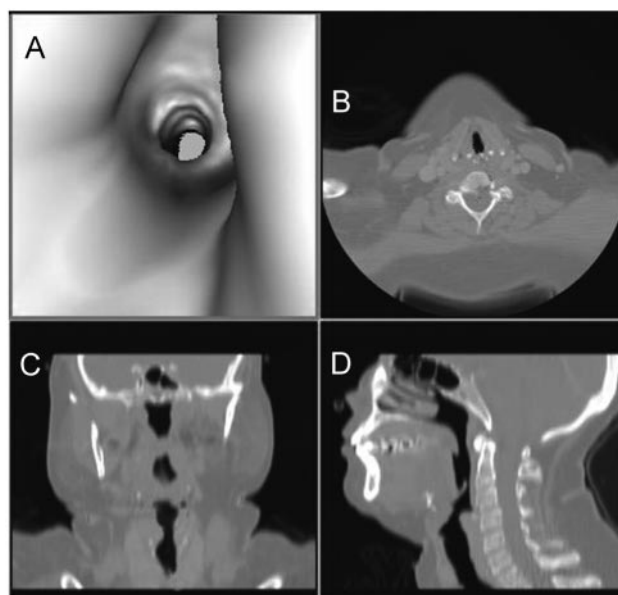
A: Virtual bronchoscopy (reformatting of computed tomography images), showing the stenosis. B: Axial slice. C: Coronal view. D: Sagittal view.
